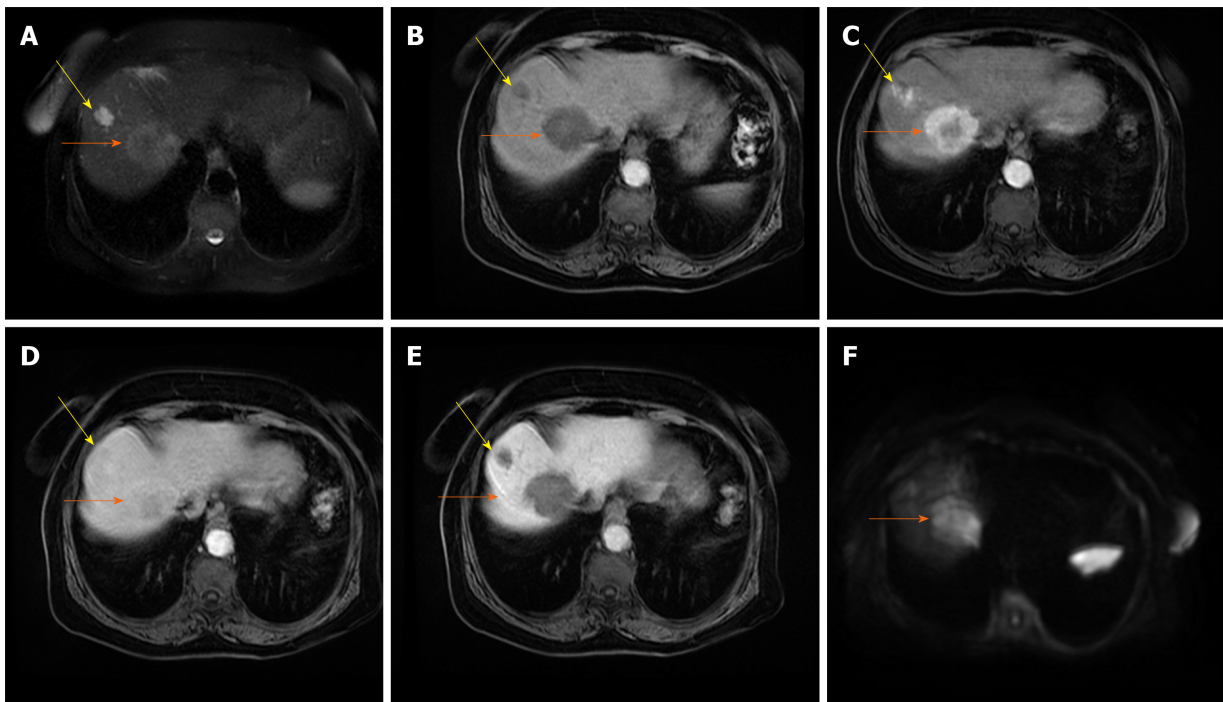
Combined hepatocellular carcinoma and cholangiocarcinoma in 65-year old woman without chronic liver disease. A: Axial T2-weighted image shows lobulated heterogeneous mass (orange arrow) located centrally in segments VII and VIII; B-D: The tumor is hypointense on T1-weighted fat-saturated image (B), with thick rim of enhancement on arterial phase (C) and progressive enhancement on portal venous phase (D); E and F: The tumor (orange arrows) is hypointense on hepatobiliary phase (E) and hyperintense on diffusion-weighted image (F). Note also hemangioma peripherally in segment VIII (yellow arrow).
